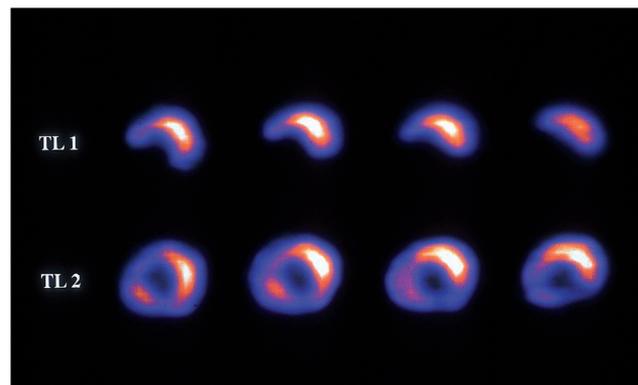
Corresponding series of ²⁰¹Tl rest-redistribution SPECT short-axis slices for assessment of myocardial viability. Early slices (top) show defect in inferoseptal wall, with redistribution on late slices (bottom). Figure reproduced from reference 5.
